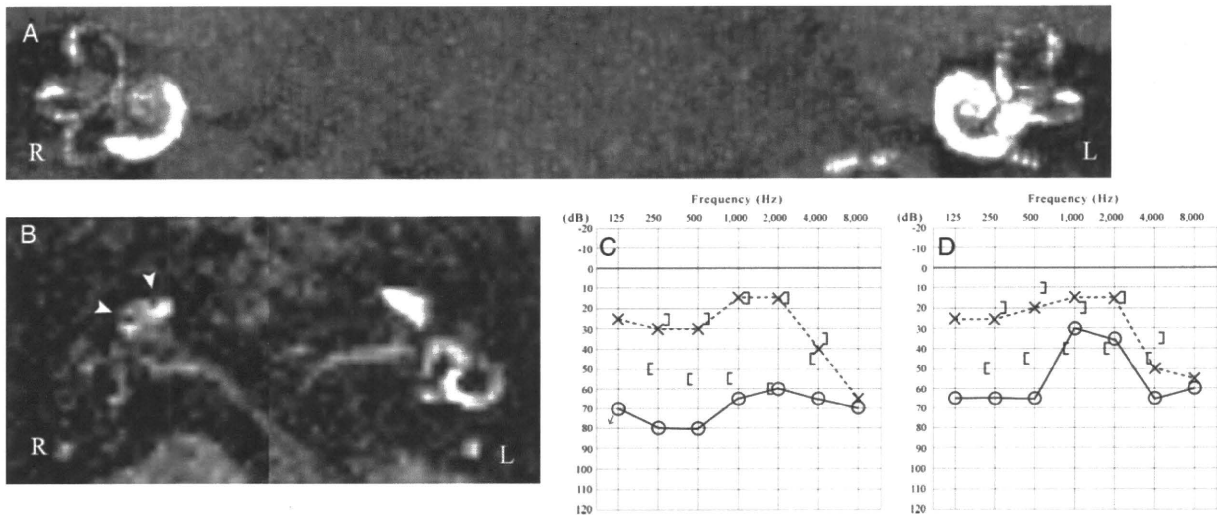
MRI before therapy. (A) The areas enhanced by gadodiamide in the cochlea and vestibule were measured using multi-planar reconstruction (MPR) image by imaging analysis software, and the affected side/unaffected side ratios were calculated. (B) The black area inside the perilymphatic space in the basal turn of the left cochlea that is filled with gadodiamide is the endolymphatic hydrops. On the contralateral side, the endolymphatic space is a significantly small area that is not detectable, likely because of the strong signal intensity in the perilymphatic space. (C, D) Pure tone audiogram: (C) before and (D) after glycerol test.
